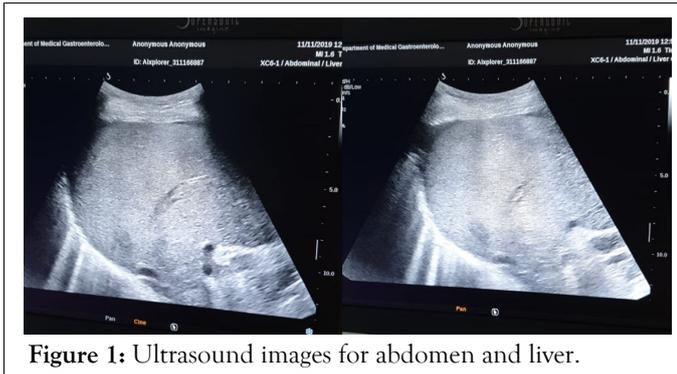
Ultrasound images for abdomen and liver.
